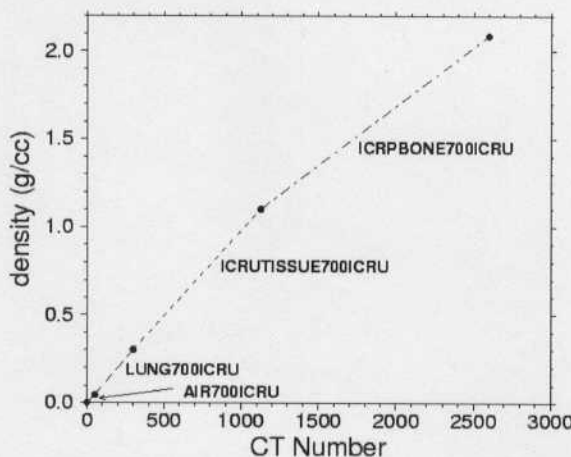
The DOSXYZnrc default ramp for converting CT-number to material density (Taken from [35]). Indicated in the figure are the ICRU standardized points for “Air”, “Lung”, “Tissue” and “Bone”.
